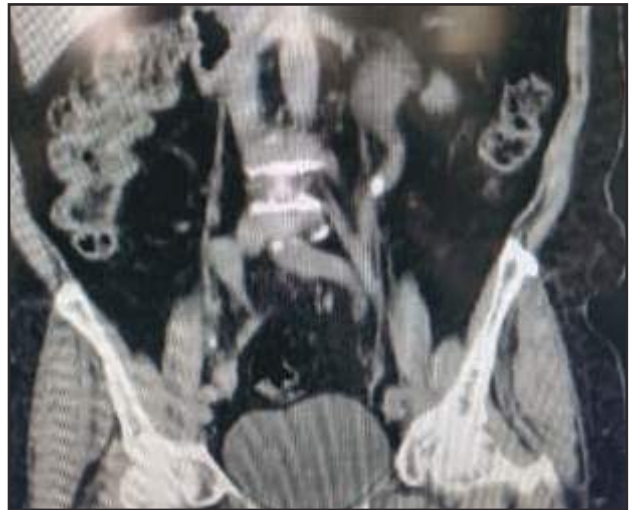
CT scan image from patient with ureteral stone in left side
